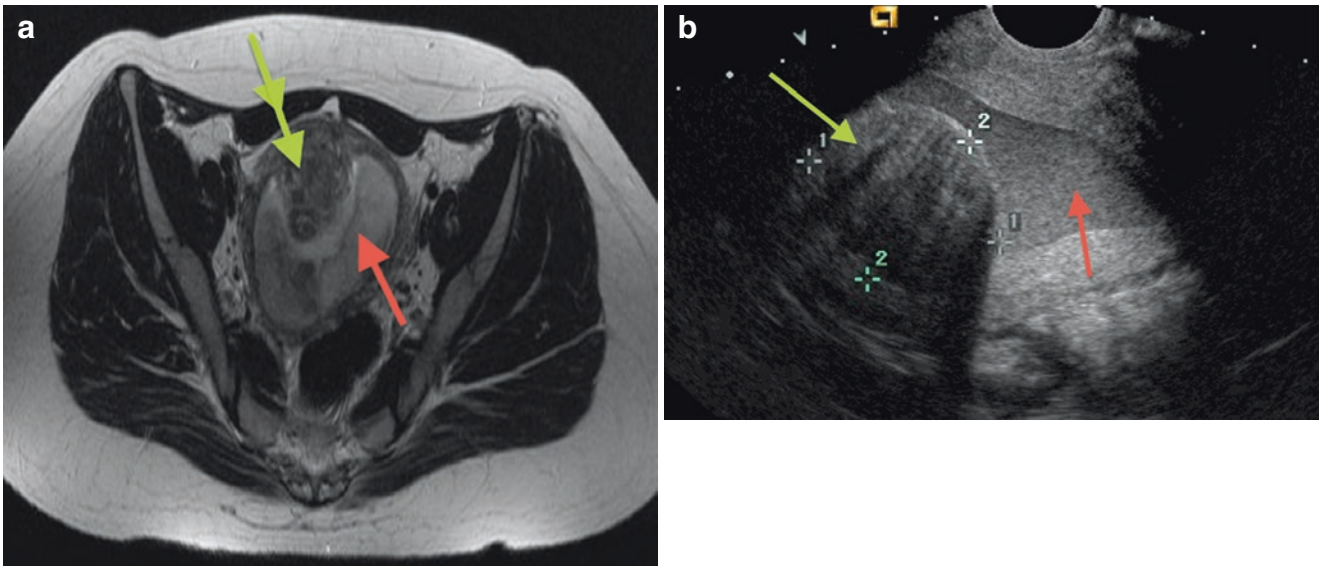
Submucosal and intramural myoma (*green arrows*), and uterine cavity (*red arrow*), filled with thick liquid. In (a) MRI of the pelvis, axial section of image weighted in T2, showing heterogeneous uterine nodule, with hyposignal. In (b) ultrasound image of the same case
